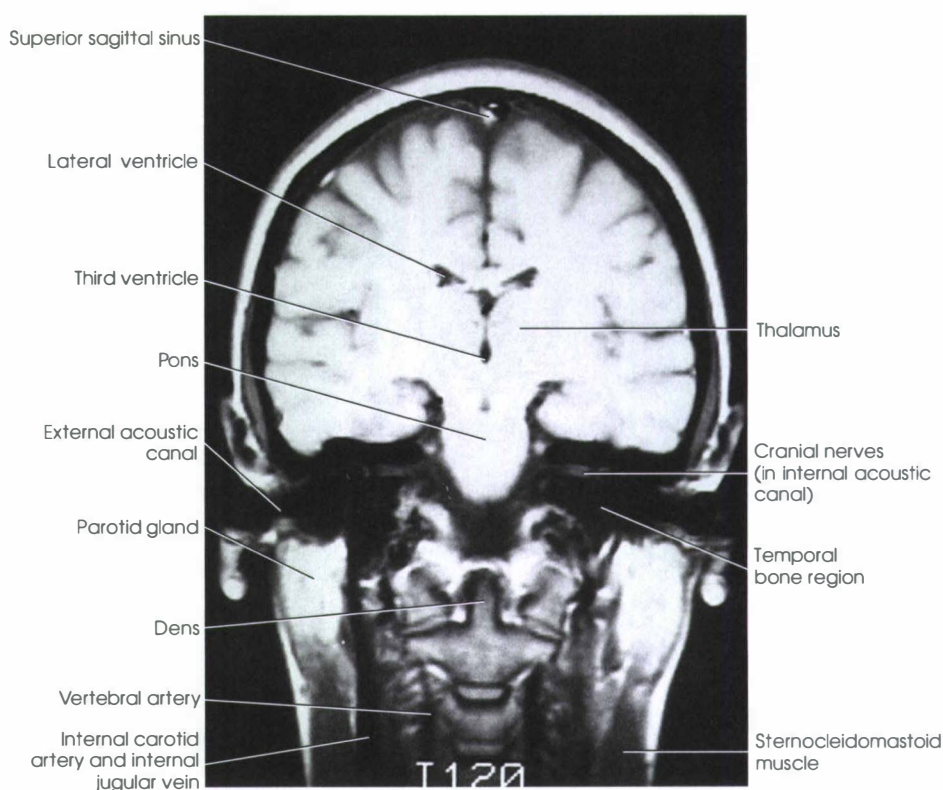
Coronal MRI corresponding to level B in Fig. 27-14.
